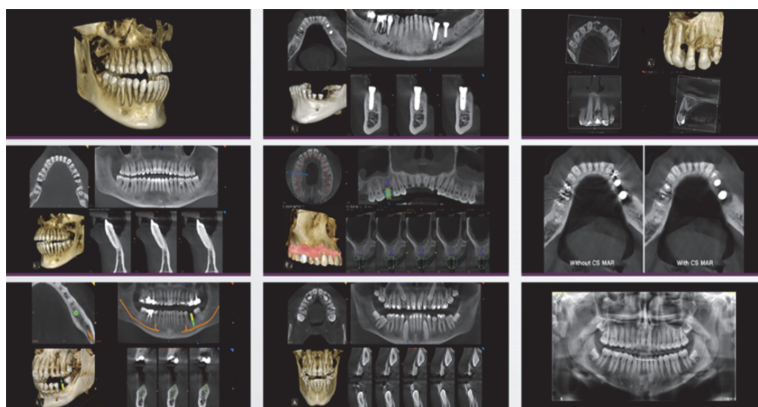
Viewing the entire dentition using a CBCT image
